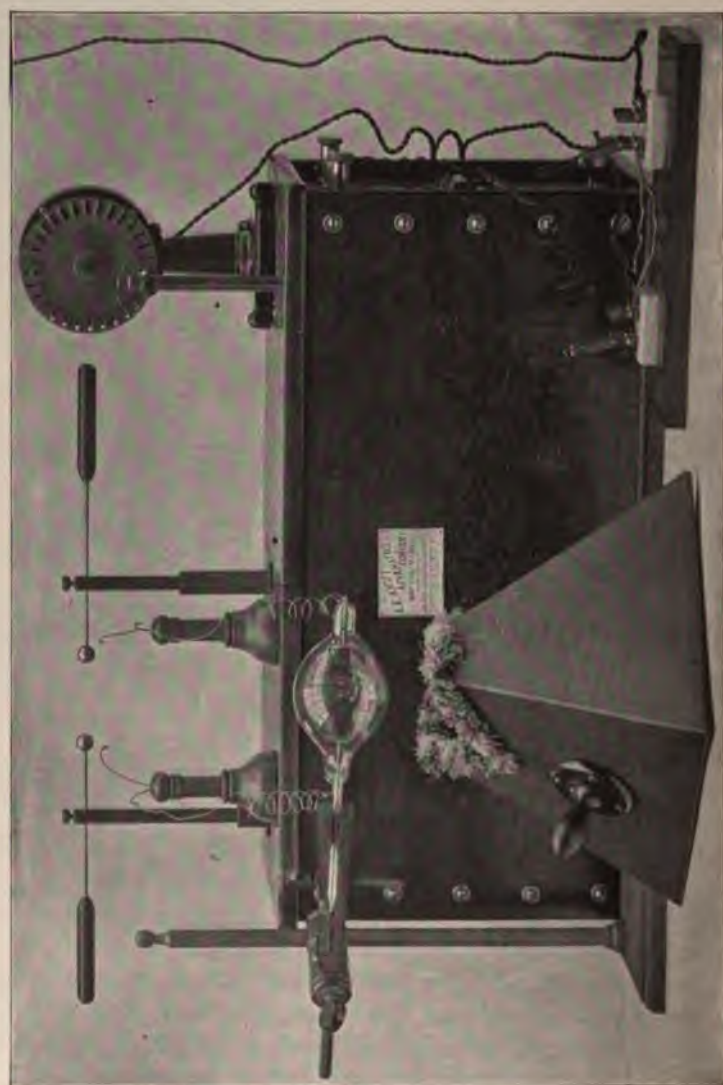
The Knott X-Ray Apparatus.
